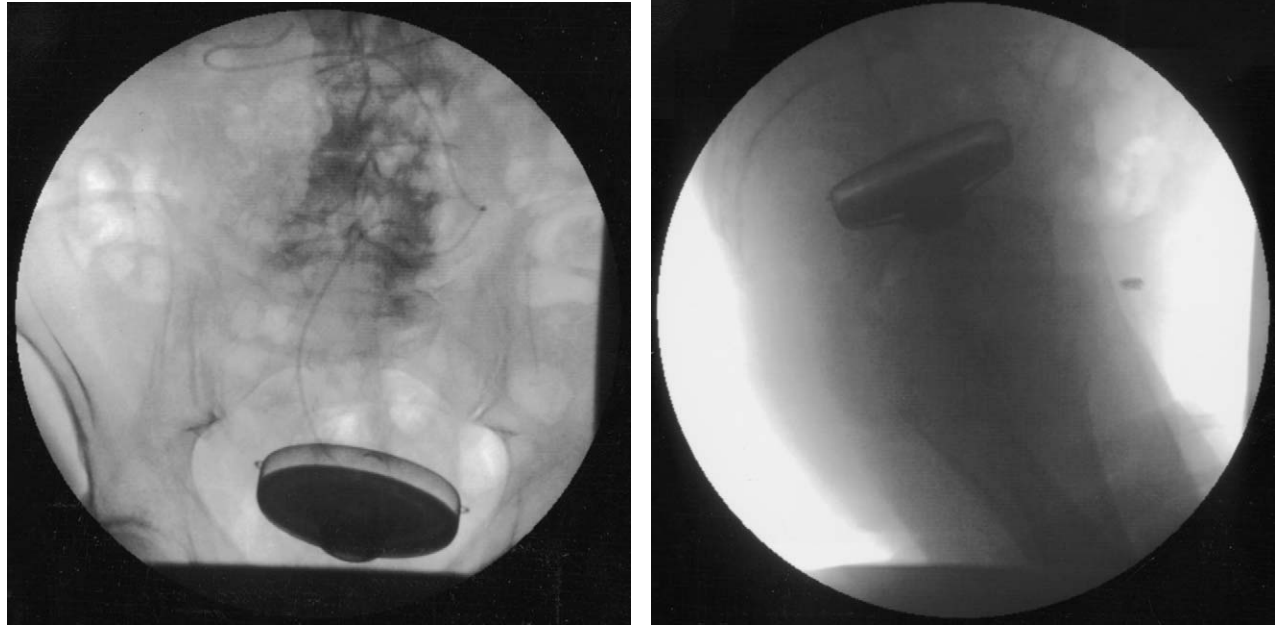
Anteroposterior (left) and lateral (right) pelvic roentgenograms, taken 4 months after the operation, show the patient's infusion pump now to be located in the true pelvis.
